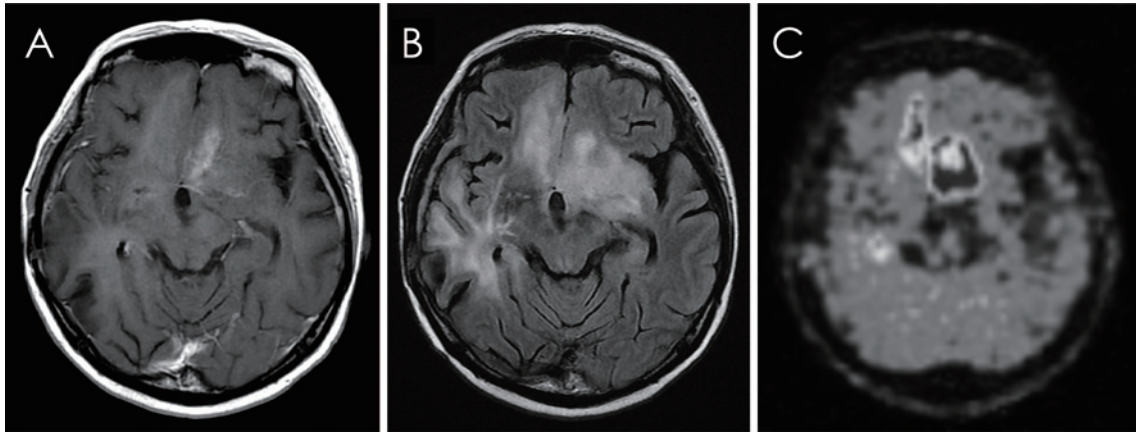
(A, B) MRI reveals a new Gd-enhanced lesion on the left ventromedial frontal lobe and high-intensity signals on FLAIR imaging. (C) ^{11}C -methionine PET shows increased methionine uptake on the lesions.
